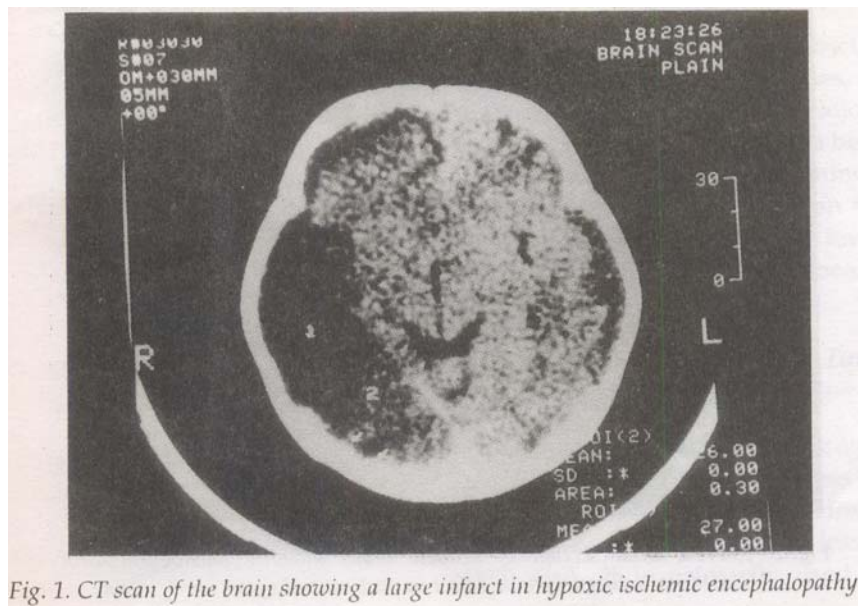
CT scan of the brain showing a large infarct in hypoxic ischemic encephalopathy.
